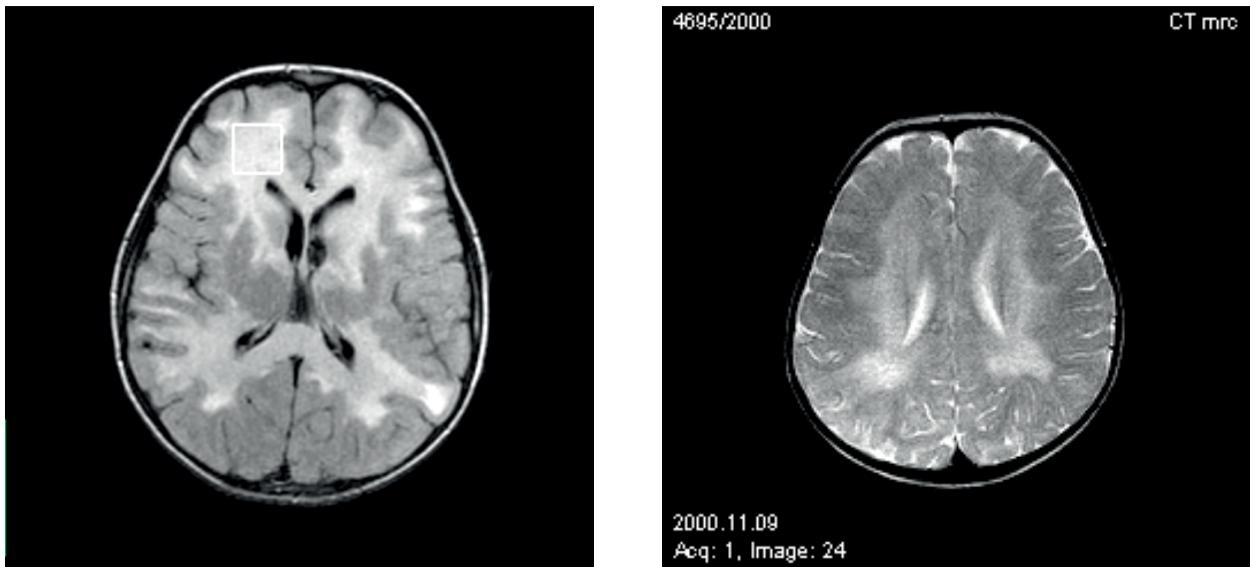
MRI scan of patient with X-ALD (left) in comparison to MRI presentation of a patient diagnosed with metachromatic leukodystrophy (right)
